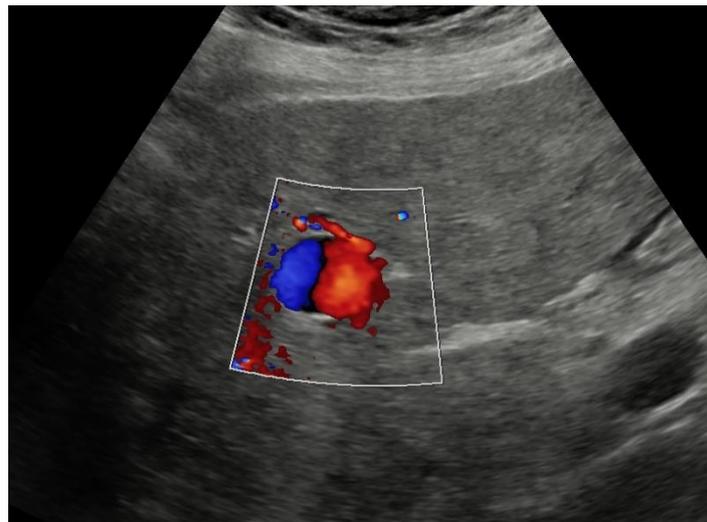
Color Doppler imaging of the same lesion reveals the pathognomonic "yin-yang" sign. This finding indicates internal turbulent venous flow and confirms the vascular nature of the lesion
